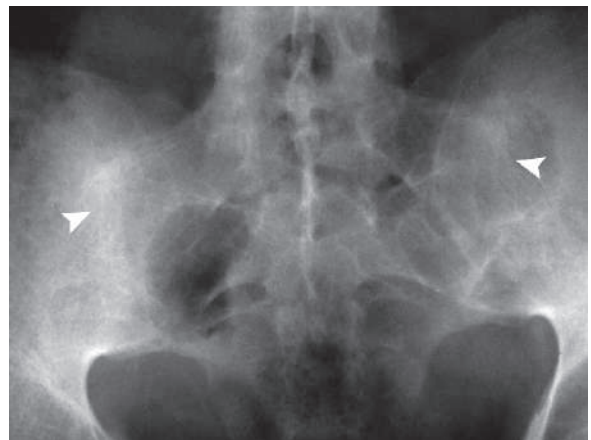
Anteroposterior plain radiograph of the hip of a patient with advanced ankylosing spondylitis (AS) shows complete sclerosis of the sacroiliac joints bilaterally (arrowheads)
